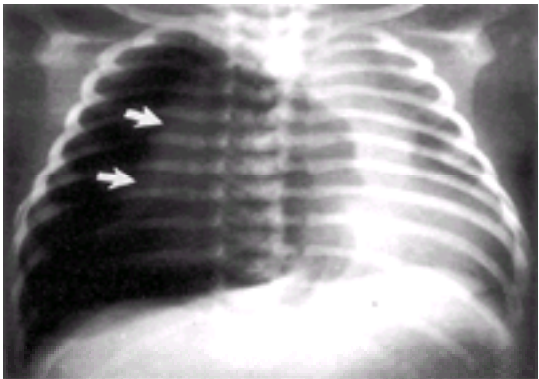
Chest radiograph of an infant with a spontaneous pneumothorax. The collapsed lung can be readily seen (arrows) when a pneumothorax is present, in contrast with a pulmonary cyst or congenital lobar emphysema when the normal lung tissue is compressed by the air-filled cyst or lobe.
